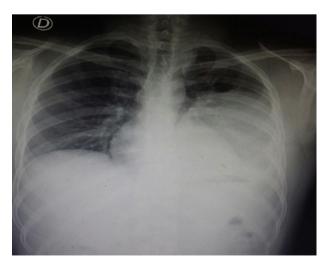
Thoracic X-ray at the time of admission. Radiopacity in the left hemithorax is observed.
